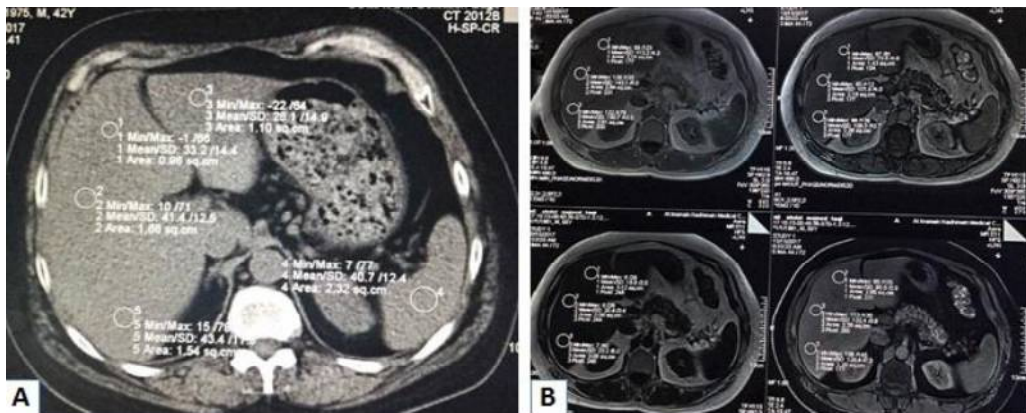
42 years old male patient, non diabetic, normal liver enzymes (ALT 38 U/L, AST 32 U/L). A: CT scan axial native image shows fatty liver (hepatic attenuation is 36 HU, spleen attenuation is 41HU). B: MRI Dixon sequence (in phase, out phase, fat only image and water only image, the calculated hepatic FF was 16.
